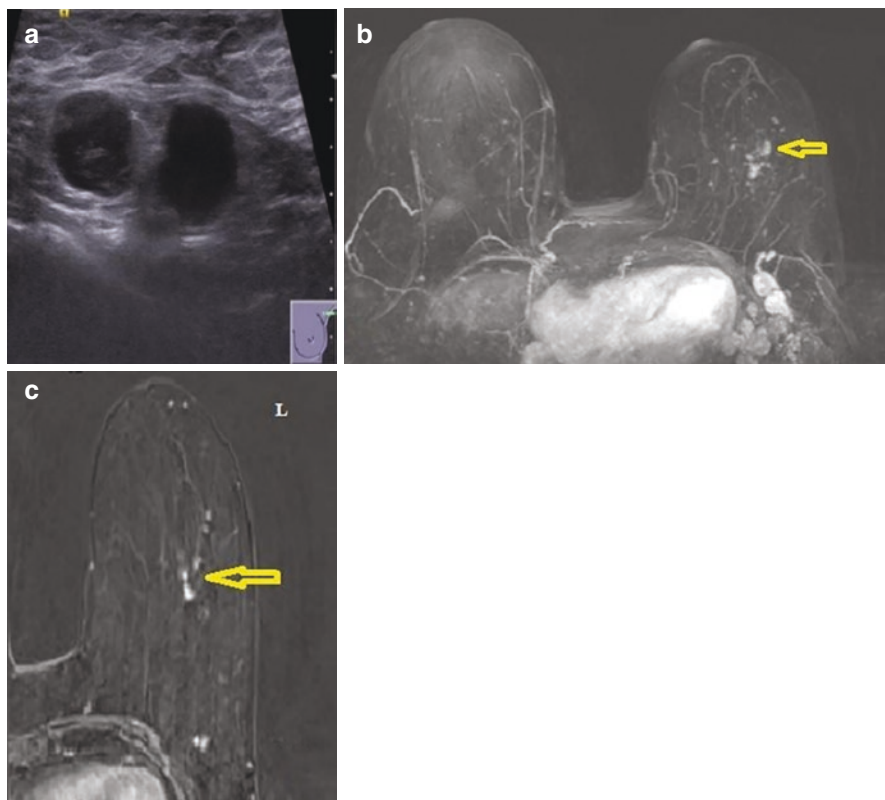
A 50-year-old lady presented with lump in the left axilla. Ultrasound (a) revealed rounded nodes with grossly thickened cortex and loss of fatty hilum. Ultrasound guided biopsy was performed for axillary node. HPE: Metastatic Lobular carcinoma with IHC profile favouring a primary from the breast. MIP (b) and post contrast T1 weighted fat-sat axial (c), images demonstrated few tiny clustered enhancing foci (yellow arrows) in the outer half of left breast which were not evident on ultrasound. HPE: Lobular carcinoma
